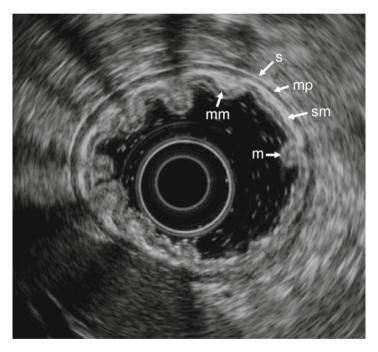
Ultrasound image of the gastric wall demonstrating five distinct sonographic layers. The superficial mucosa (m) is hyperechoic and represents the first layer. The second layer is the hypoechoic, deep mucosa, or muscularis mucosa (mm). The submucosa (sm) is hyperechoic and corresponds to third layer. The fourth layer, muscularis propria (mp) is hypoechoic. The serosa (s) is the fifth layer and hyperechoic.
